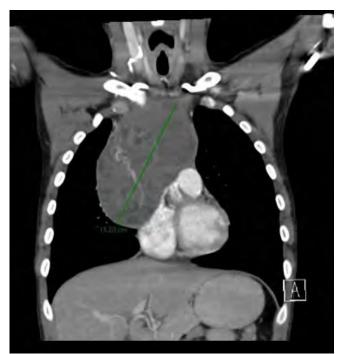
Computed tomography scan showed a mediastinal neoplasm of 11.6 cm by 8.6 cm by 15.2 cm, with a calculate volume of 800.8 cc, with superior vena cava involvement.
